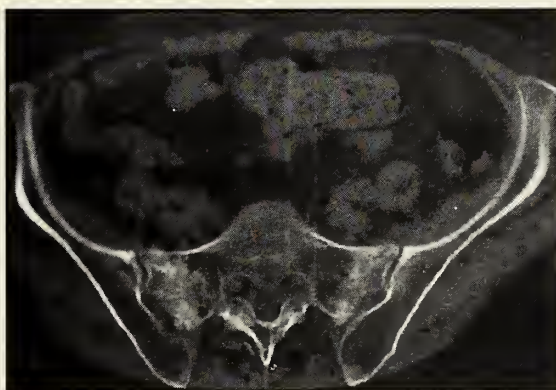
Bone algorithm CT scan of the sacroiliac joint
